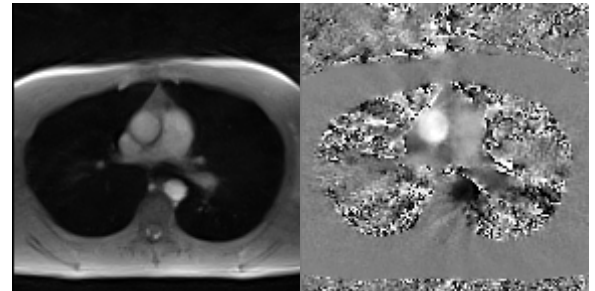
Real time PC MRI of through plane flow in aorta. (Right) Magnitude image, (Left) Phase contrast map.
